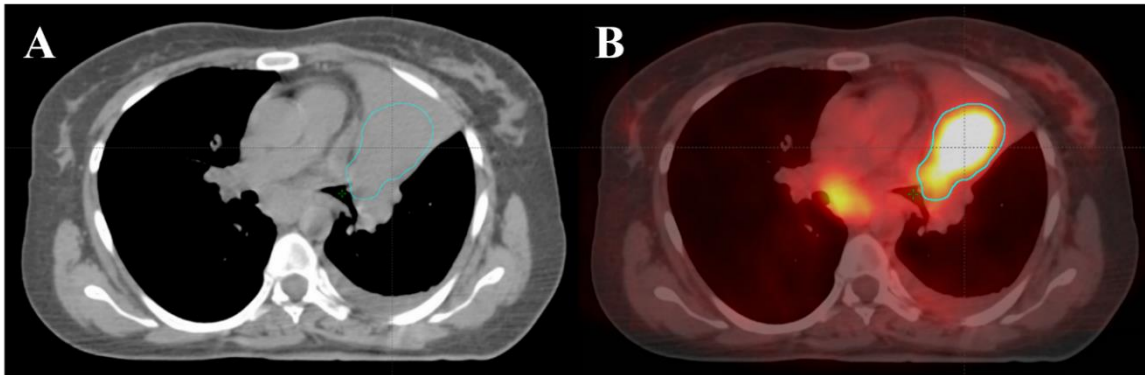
Lesion that cannot be seen on A) CT but is easily distinguished on B) fused PET/CT⁴⁰
